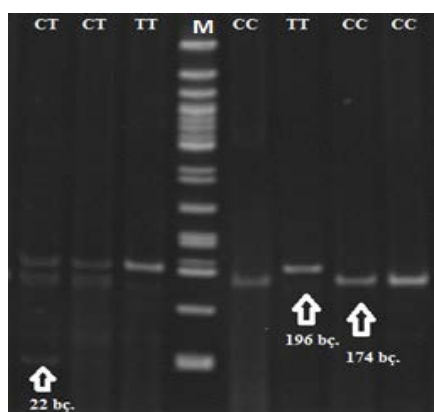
PCR-RFLP results of -590 C>T polymorphism. PCR product (196 bp), CT (196/174/22 bp), CC (174/22 bp), TT (196 bp), M marker (50 bp)
